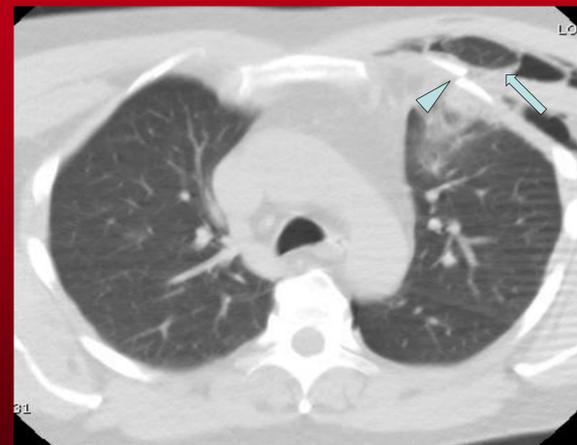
Images performed in the outside facility prior to the patient's transfer to our trauma emergency room. The chest radiograph demonstrates an ill-defined left upper lobe opacity (arrows).
